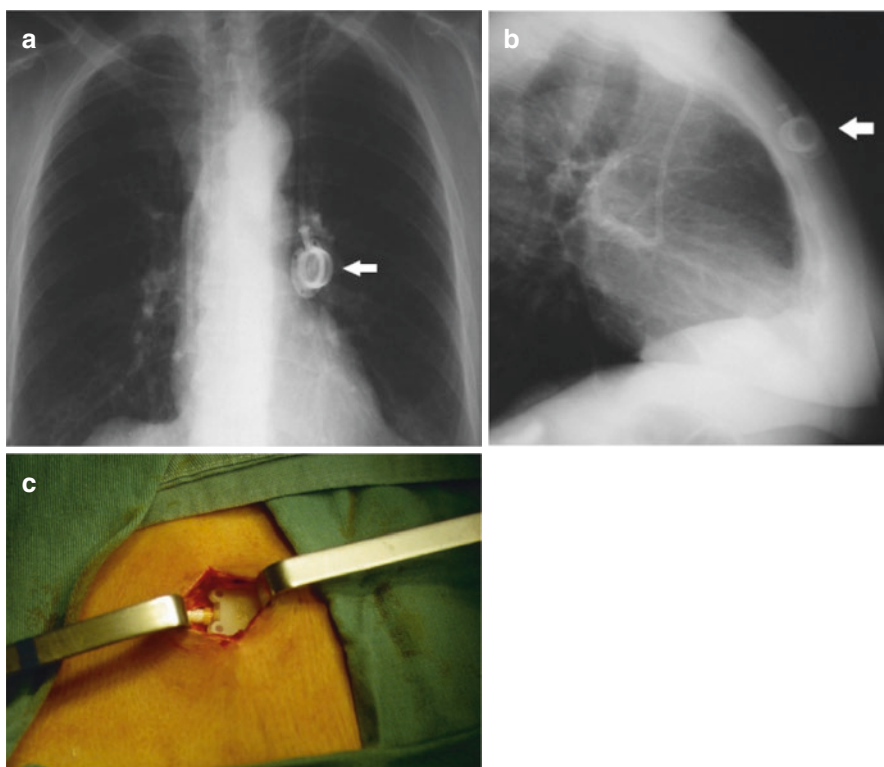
Reservoir rotation. Posteroanterior (a) and lateral chest radiography (b). Note that the rotation of the reservoir (white arrow) is more evident in the lateral view. (c) Surgical image of the reservoir rotation
